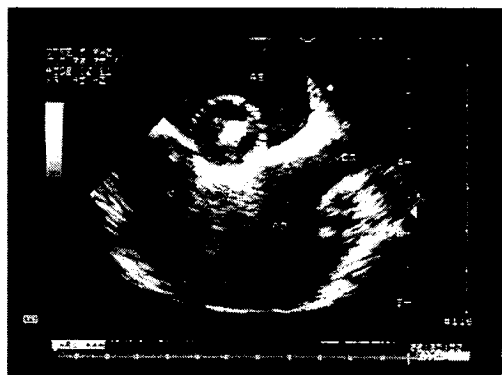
Transesophageal echocardiogram (long axis), showing the balloon positioned in the atrial septum during the measurement of the stretched diameter.
